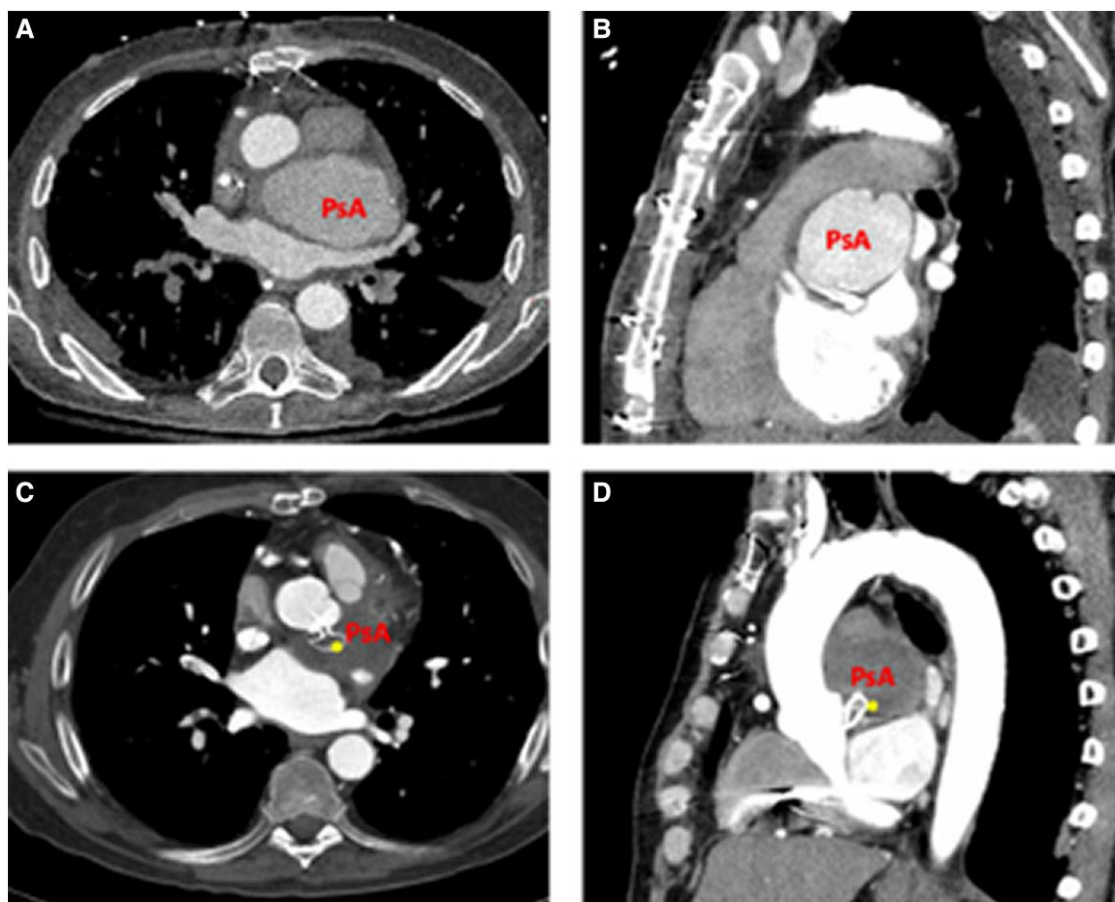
Computed tomography chest demonstration of aortic pseudoaneurysm at the sinotubular junction above the left main coronary artery. (A) Axial view of the pseudoaneurysm at time of diagnosis, (B) sagittal view of the pseudoaneurysm at time of diagnosis, (C) axial view of the pseudoaneurysm at 2-year follow-up, and (D) sagittal view of the pseudoaneurysm at 2-year follow-up. (* denotes the location of the Amplatzer atrial septal defect occluder).
